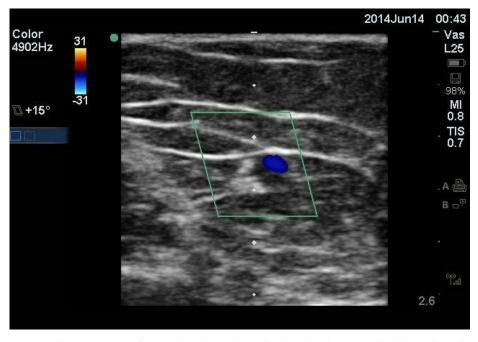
Short axis view of a peripheral vessel visualised with Colour Doppler (blue). The scale on the right of the screen demonstrates a total depth of 2.6 cm. A guide (white dots) in the centre of the screen marks each 0.5cm of depth. Therefore the depth of the vessel is between 1-1.5cm deep to the skin surface.
